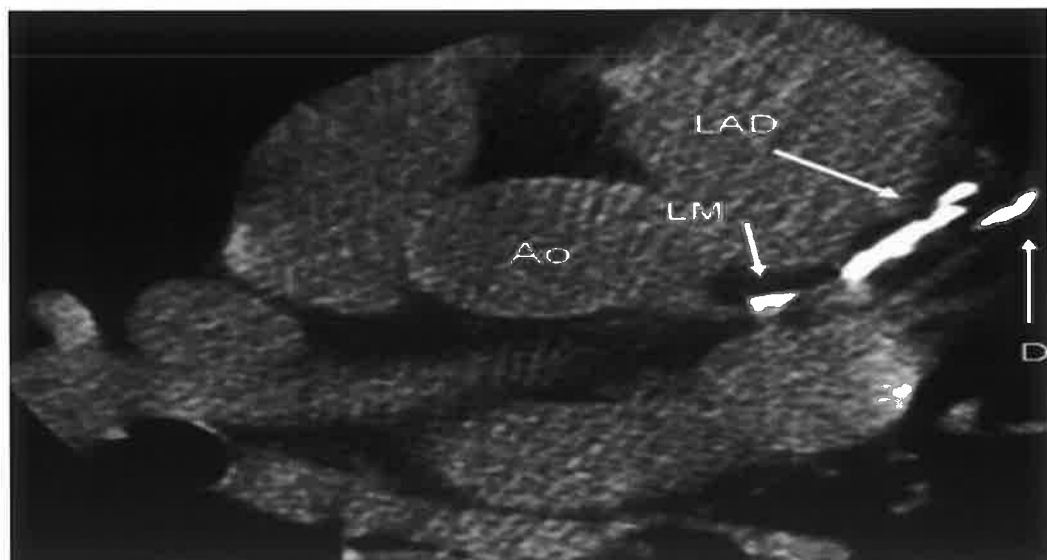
Cardiac structures on MDCT in a patient with a high CAC. Calcification is evident as a bright white colour change in the LAD and LM arteries. Adapted and reproduced with permission from Henneman et al. [74]. Ao, Aorta; CAC, coronary artery calcification; D, diagonal branch of the left anterior descending coronary artery; MDCT, multidetector computed tomography; LAD, left anterior descending coronary artery; LM, left main coronary artery.
